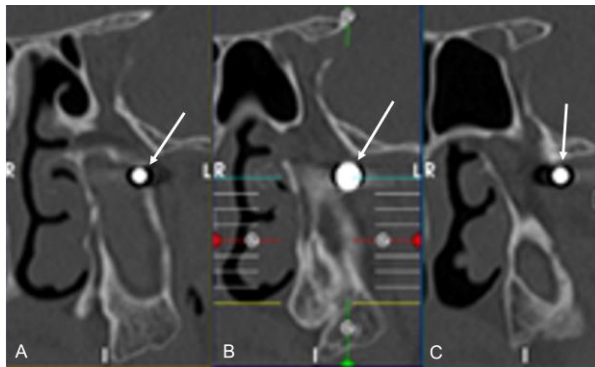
Position of the bullet in the left pterygopalatine fossa on coronal images of CT scan. A. Arrow: anterior part of the bullet is situated in the posterior wall of the left maxillary sinus. B. Arrow: major part of the bullet is positioned immediately behind the posterior wall of left maxillary sinus in the left pterygopalatine fossa. C. Arrow: minor part of the bullet is situated deeper in the left pterygopalatine fossa.
